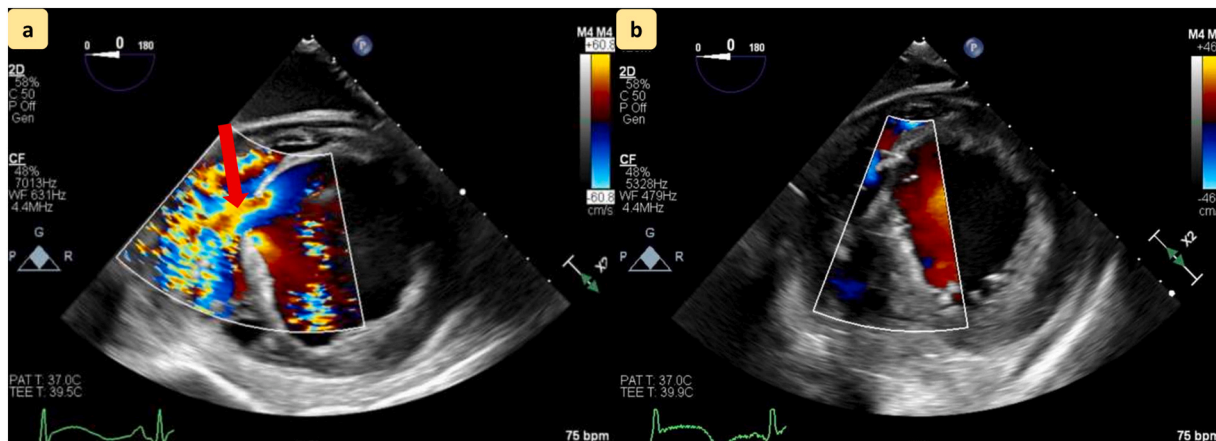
a) Intra-operative TEE transgastric short-axis view showing the muscular VSD (arrow) with color Doppler confirming left-to-right shunt. b) Intra-operative TEE transgastric short-axis view showing VSD repair without evidence of residual shunt.
